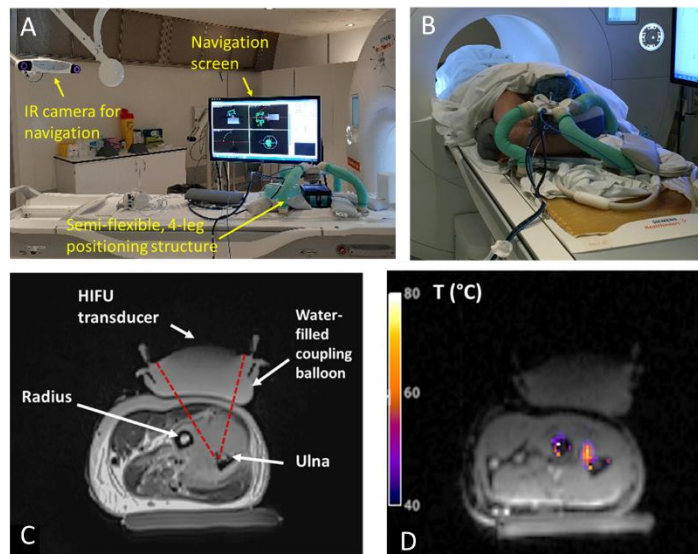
(A) General setup; (B) Experimental setup for the presented clinical case: the transducer is positioned over the forearm; (C) Transverse MR image showing the HIFU transducer, and the target on the ulna; (D) Real-time MR Thermometry during the ablation
